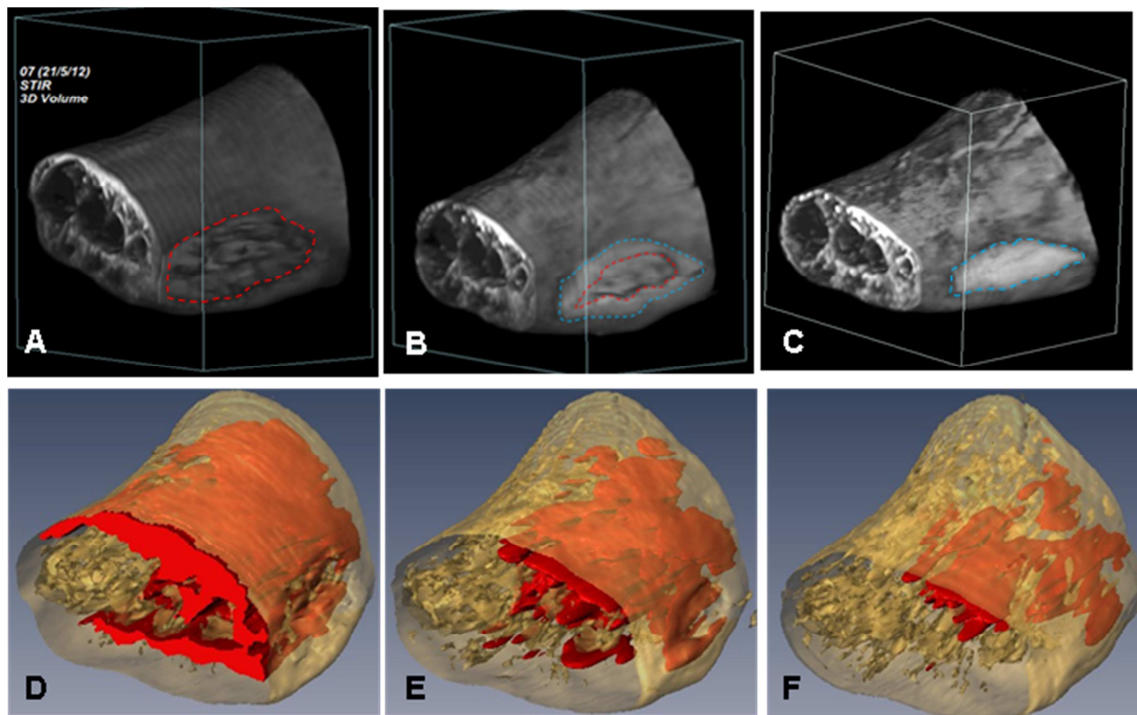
MRI STIR 3D Reconstruction. Wound (A-C) and Edema (D-F) Changes during EGF Treatment: A and D: before Treatment; B and E: Week 6 after Treatment; C and F: Week 10 after Treatment. The Calculated Edema Volumes were 137 cm³ (D), 94 cm³ (E) and 54 cm³ (F).
